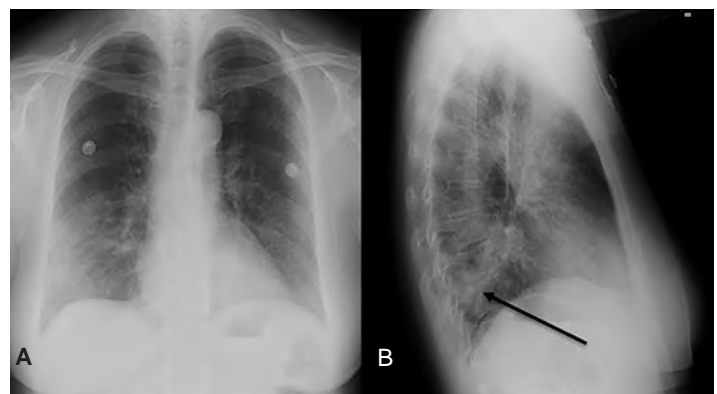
Chest radiographs of the initial emergency department visit. Patient was dyspneic at the time. A) Posterior-anterior view demonstrating prominent interstitial markings in the mid and lower lung field bilaterally; and B) Lateral view with apparent area of retrocardiac opacity (arrow) likely representing an early consolidation in the left lateral lobe.
